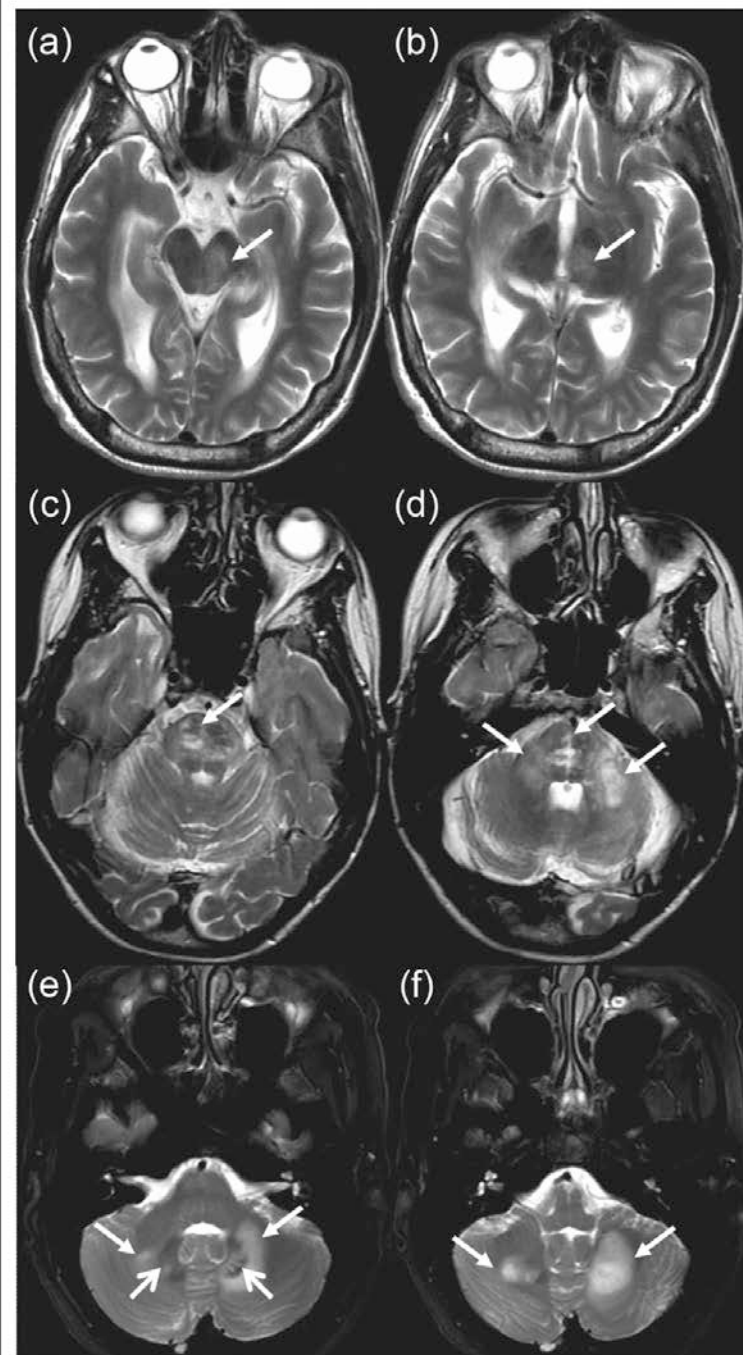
Examples of intratentorial PML lesion manifestations. Axial T2-weighted MR images of three patients ((a)–(f)) with natalizumab-associated PML presenting with intratentorial lesions in the acute PML stage. (a), (b): A lesion located in the left thalamus is spreading into the left mesencephalon (cerebral peduncle). (c), (d): multifocal PML lesions in the posterior fossa located in the pons (brachium pontis) and in both middle cerebellar peduncles. (e), (f): Lesion located in the cerebellar hemispheres (closed-head arrow) also affecting the dentate nucleus (open-head arrows). PML: progressive multifocal leukoencephalopathy; MR: magnetic resonance.
